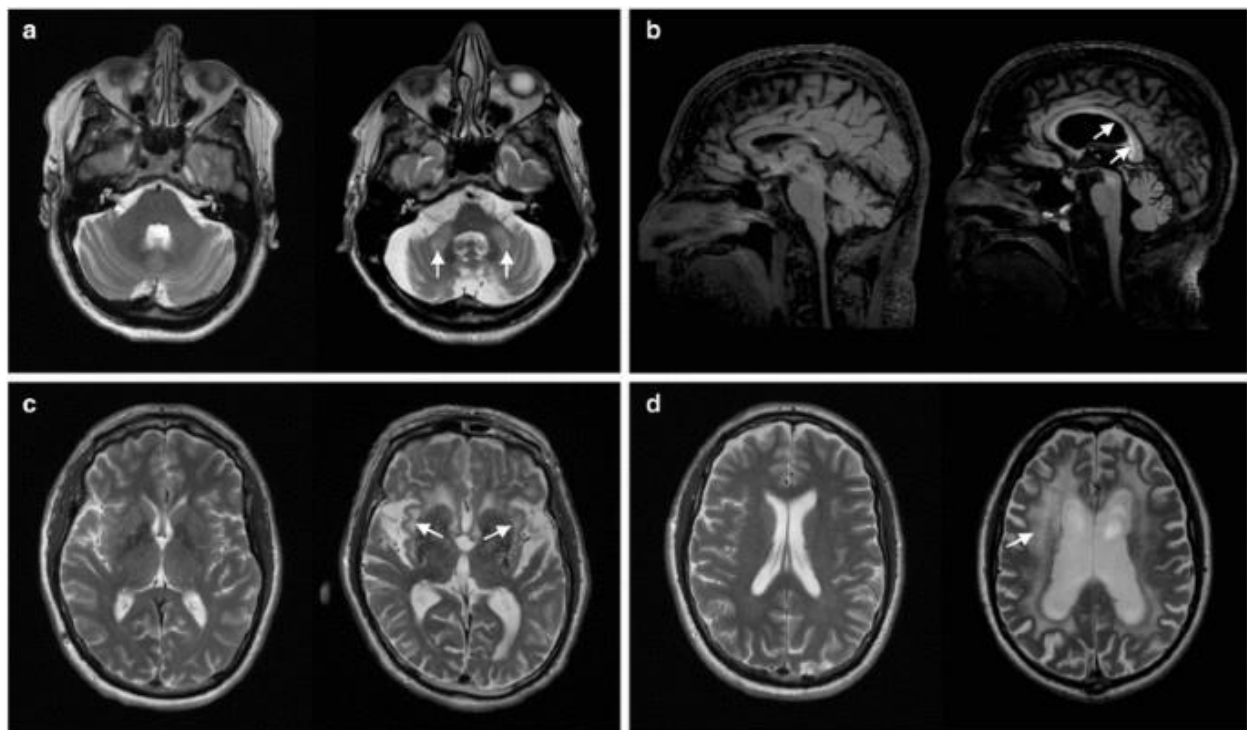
MRI images of white matter lesions and structural abnormalities associated with FXTAS. Image containing four panels where each panel represent pair of image, a normal control (left) and FXTAS case (right). The white arrows indicate increased signal intensity on T2 turbo spin-echo sequences in the middle cerebellar peduncle (MCP) (a), sub-insular white matter
